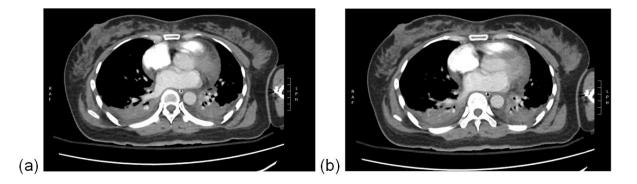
a&b: CT thorax showing small segmental pulmonary embolism at R lower lobe.
